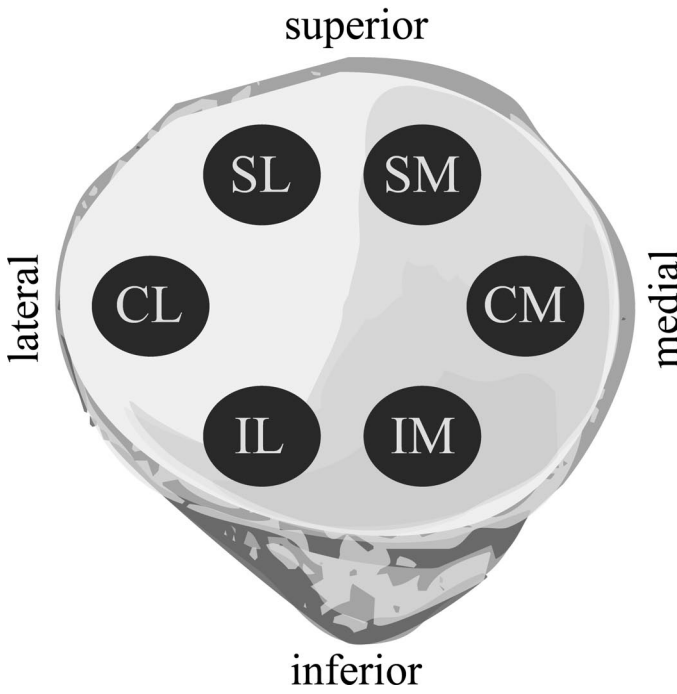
The ultrasound measurement sites on a human patellar cartilage surface. SL = superolateral, SM = superomedial, CL = central lateral, CM = central medial, IL = inferolateral, and IM = inferomedial.
